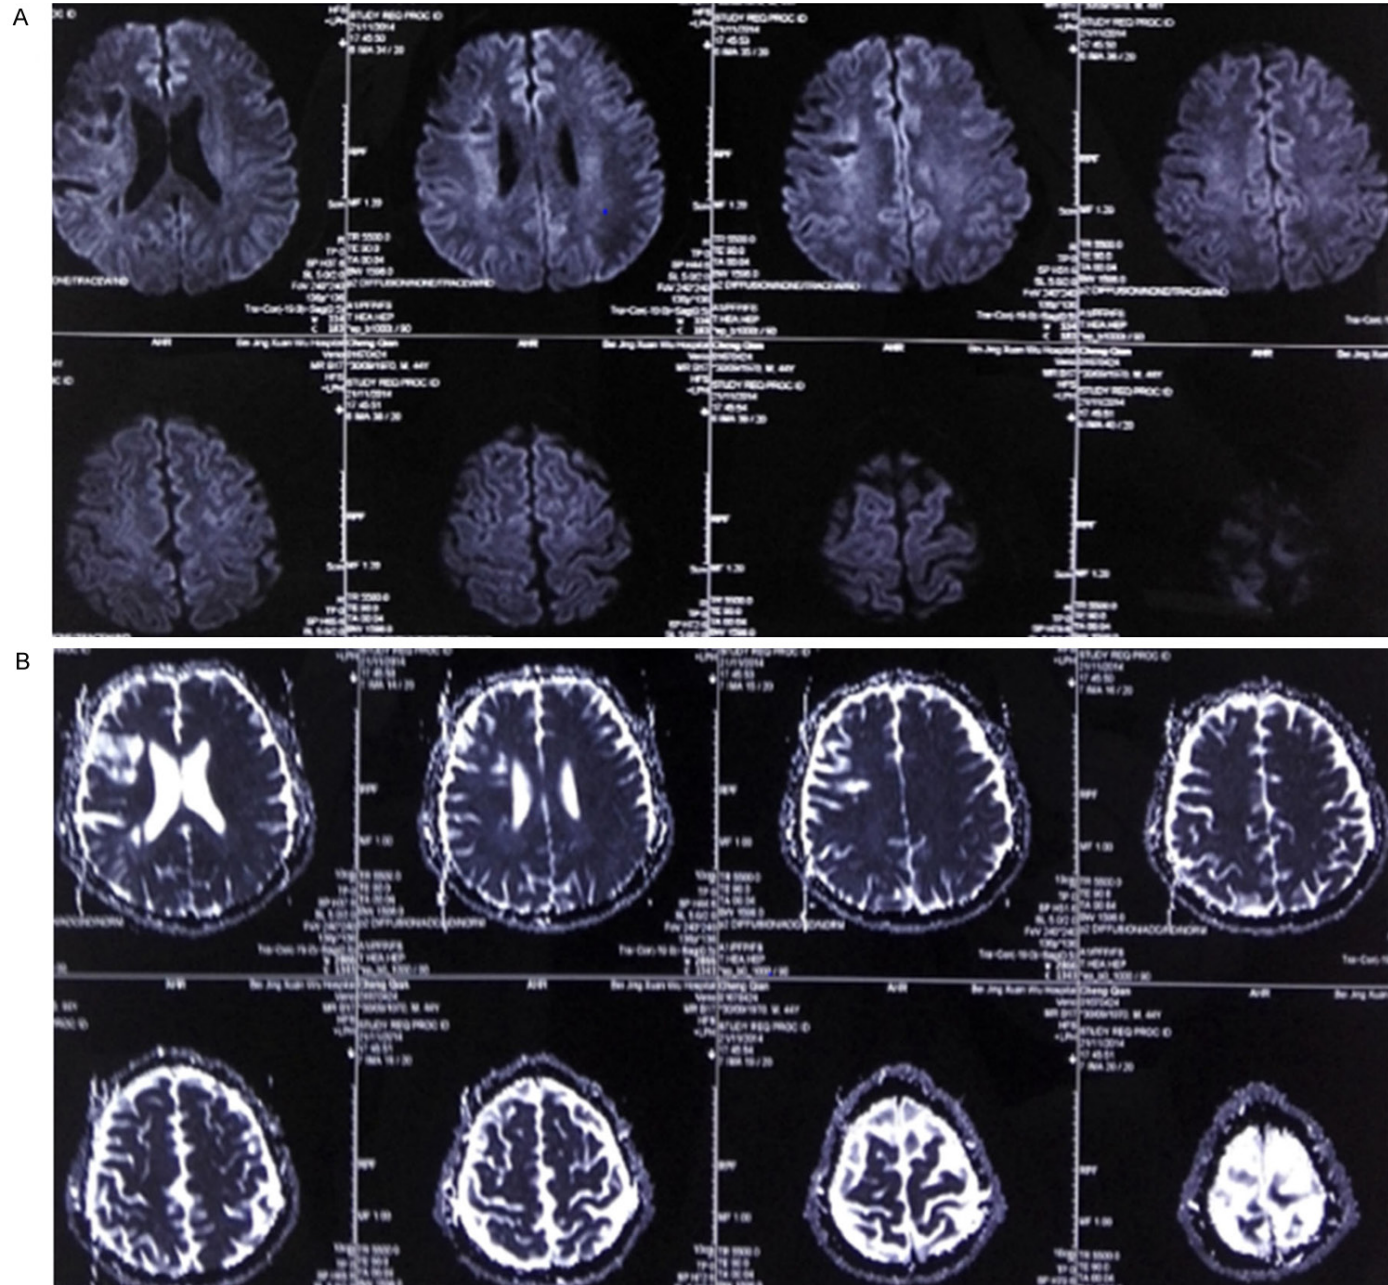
Postoperative cerebral MRI (A. DWI; B. ADC).
